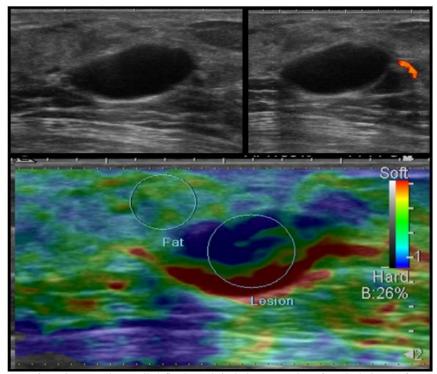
Simple Breast Cyst. On B-Mode a well defined anechoic lesion suggestive of cystic lesion (Left Upper corner). Doppler ultrasound showed no vascularity within the lesion (Right Upper Corner). Elastography showed BGR pattern i.e. blue, green and red according to Tsukuba scoring method (Lower Image).
